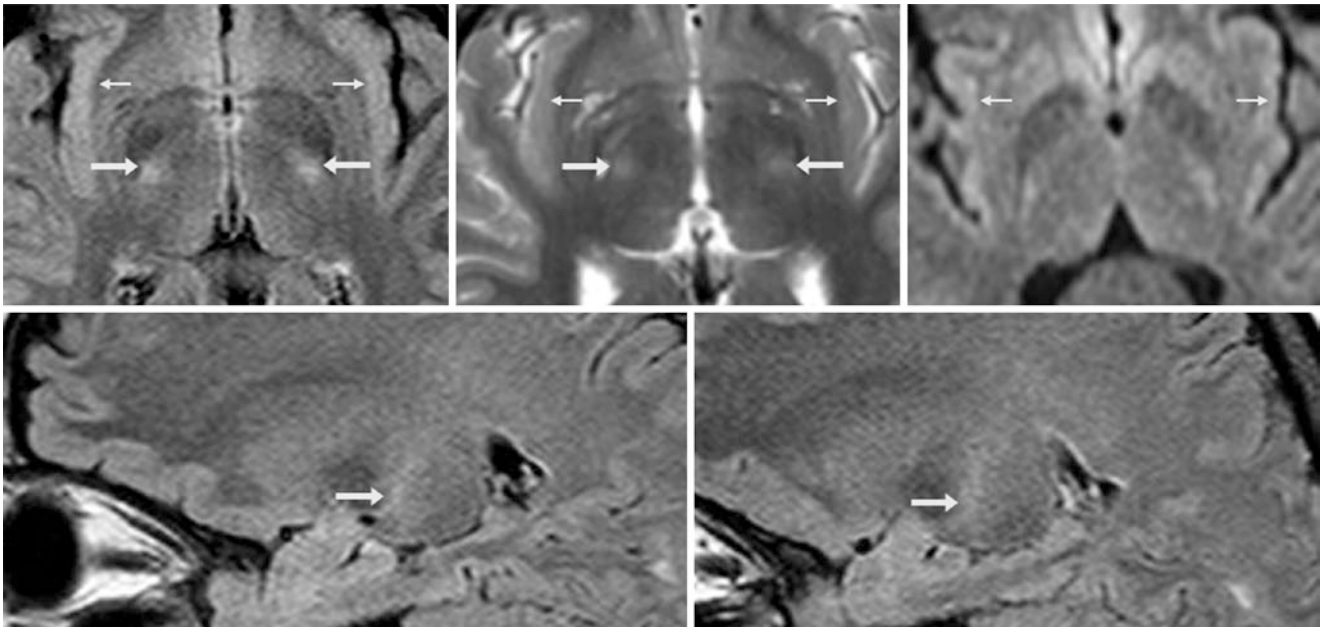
A 19-year-old with headaches had a normal 1.5 T MRI with FLAIR (*top left*) and T2WI (*top middle*). There is mildly bright signal within the CSTs (*arrows*) and insula (*thin arrows*) bilaterally, somewhat prominent for a 1.5 T MRI, but such signal in these sites is normal. DWI (*right*) did not show such hyperintensities, and the ADC maps
